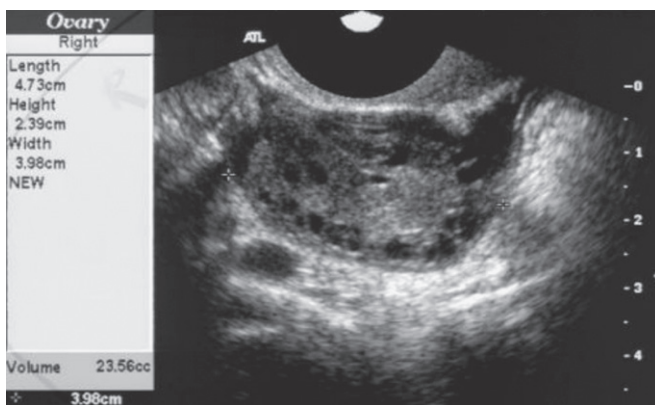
Transvaginal ultrasound of the right ovary
